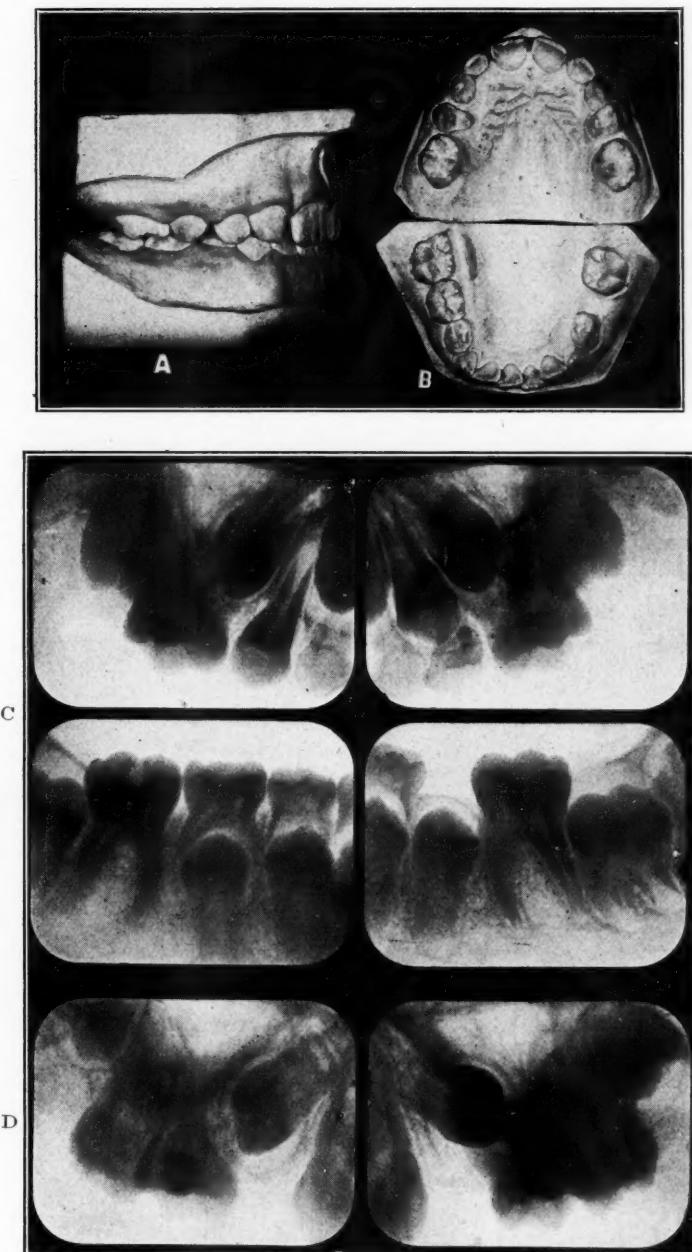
Patient aged nine years, eleven months. *A*, Right side in occlusion. *B*, Occlusal view. Normal occlusion except for probable premature loss of $5|5$ (the history says about sixteen months previously). It has resulted in forward movement and rotation of $6|6$ so that $64|$ and $|6$ are in contact; $5|5$ will be shut out of the arch. The treatment is to remove these teeth; no other treatment should be necessary to obtain a satisfactory alignment and occlusion. If $4|4$ are removed, as has been done, $6|6$ are liable to move medially before $5|5$ erupt, so the space for them should be retained, and if they erupt lingually, they must be moved into line. *C*, Radiographs show that all the permanent teeth are present.
